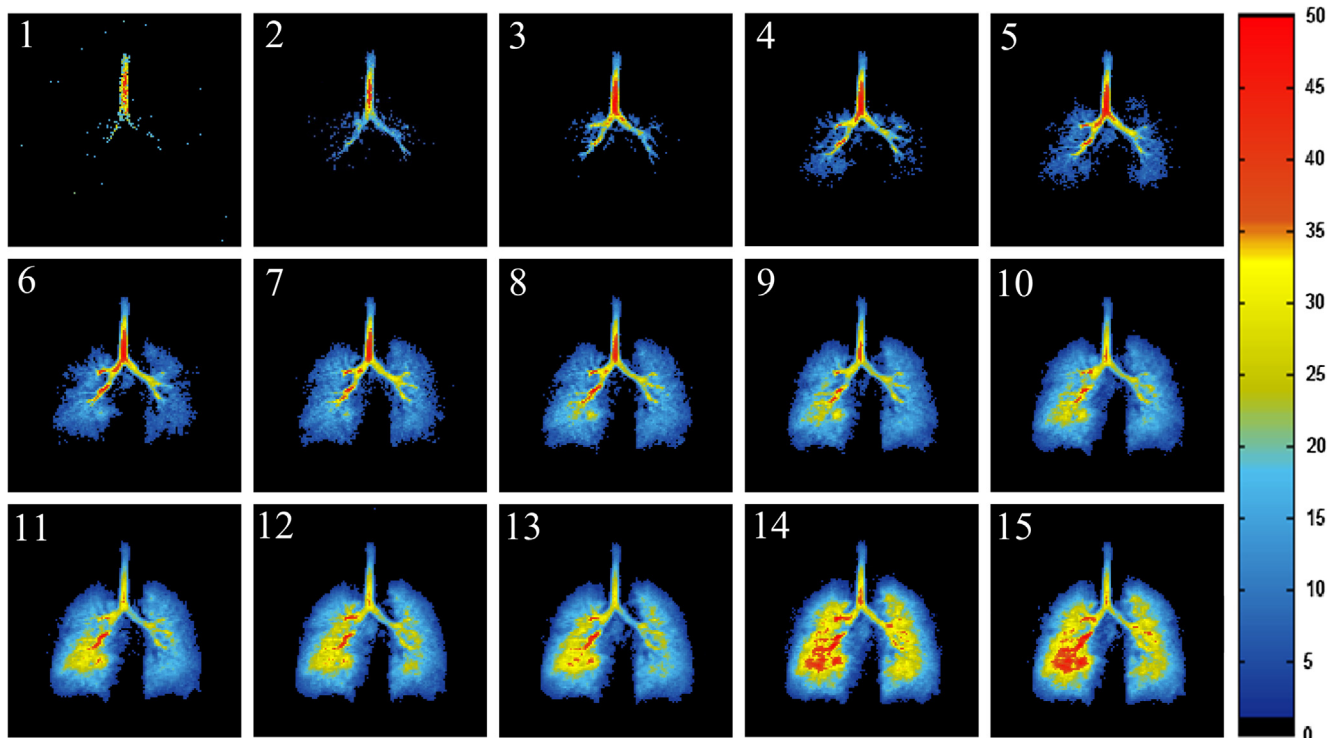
15 frames of *in vivo* dynamic ^{129}Xe MR images of a healthy volunteer obtained using the proposed method.
